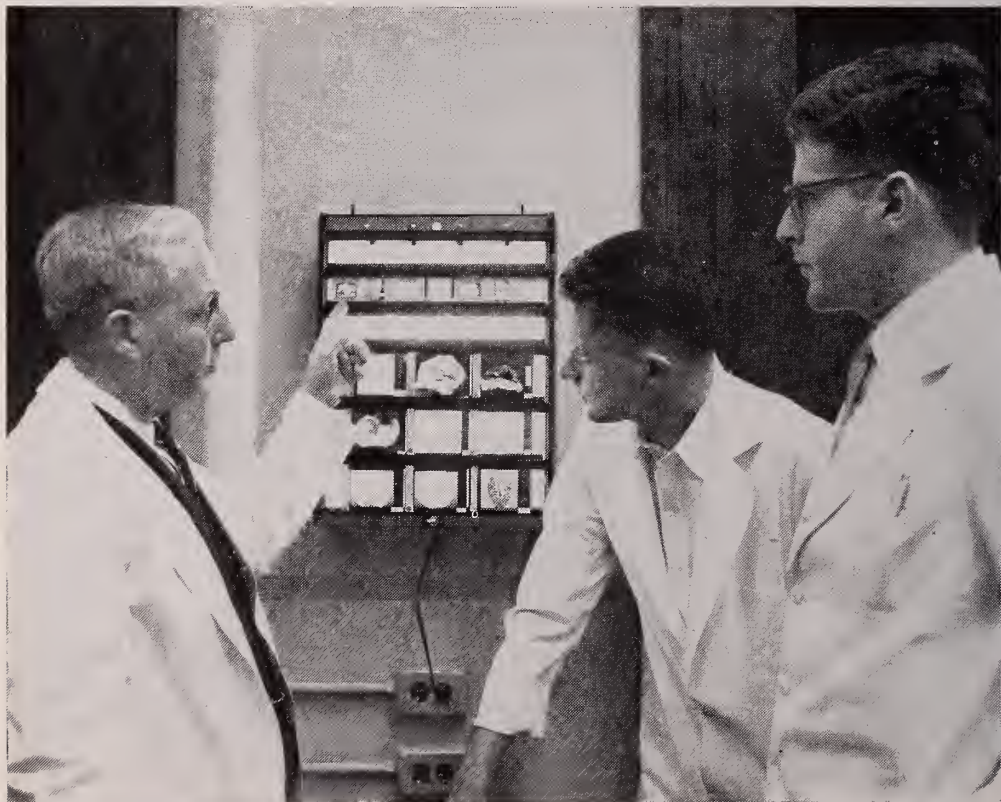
The x-ray viewing box in D 301A (all rooms are so equipped) modified to hold lantern slides for special demonstrations. The rack is removable so that the box may be used for viewing x-ray films.
